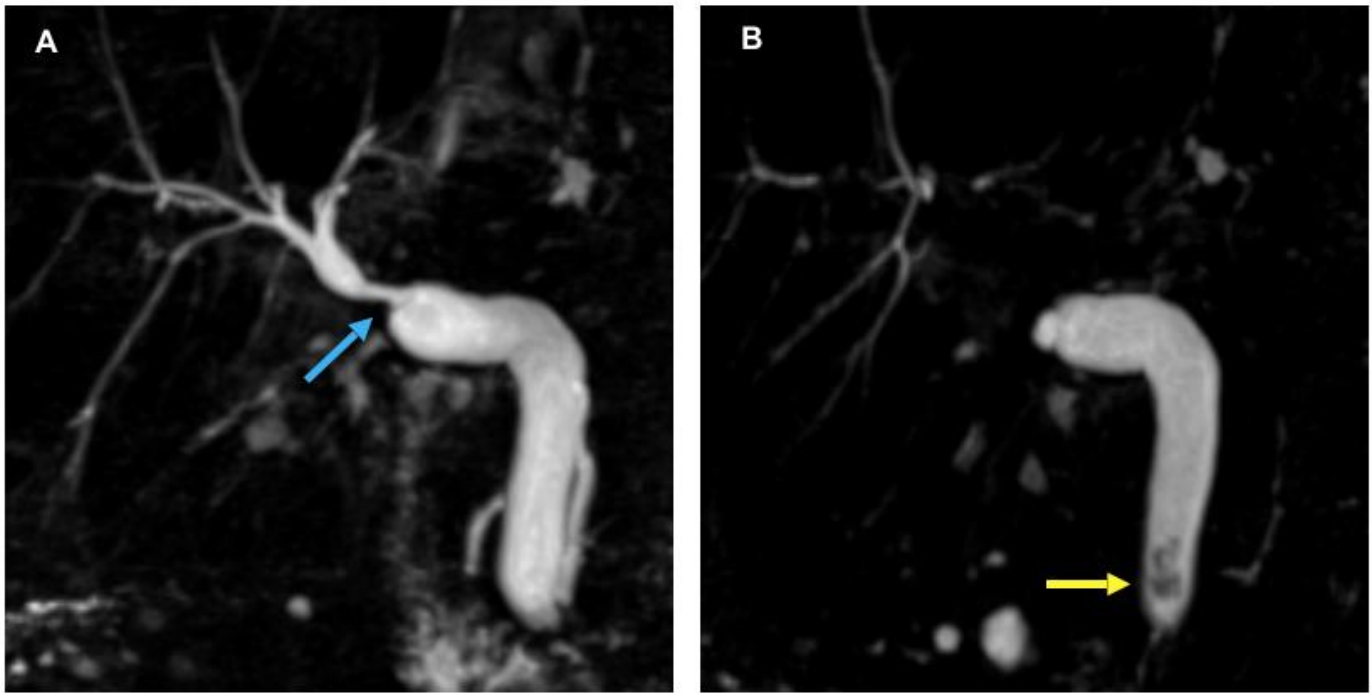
69-year-old female underwent liver transplant for primary biliary cirrhosis. A duct-to-duct biliary anastomosis was performed and a donor-to-recipient size mismatch was noted at surgery. Developed rising alkaline phosphatase 3 weeks post transplant and ultrasound showed mild intrahepatic duct dilatation. (A) Subsequent MRCP demonstrates donor-to-recipient duct discrepancy with patent lumen at the anastomosis (blue arrow). (B) Filling defects were present within the distal CBD at the level of the ampulla (yellow arrow) that proved to be stones at ERCP. Liver function improved to normal after biliary clearance.
